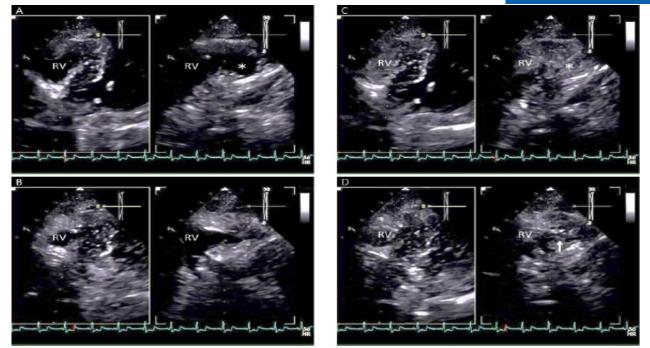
Contrast Transthoracic Echocardiography: Biplane images based on right ventricular modified apical four-chamber view suggest an apical chamber at end-diastole (A, asterisk), which is difficult to assess at end-systole (B). On contrast echocardiography with agitated saline, the small apical chamber is filled with micro bubbles at end-diastole (C, asterisk), and some bubbles stayed in the chamber even at the end-systole (D, arrow).
